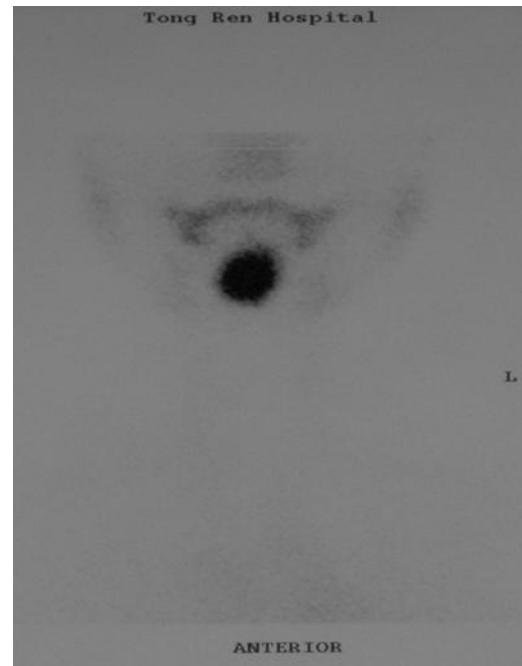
^{99m}Tc -pertechnetate thyroid scintigraphy of the 36-year-old woman showed a round uptake area at the root of tongue with the absent uptake in normal pretracheal region.
